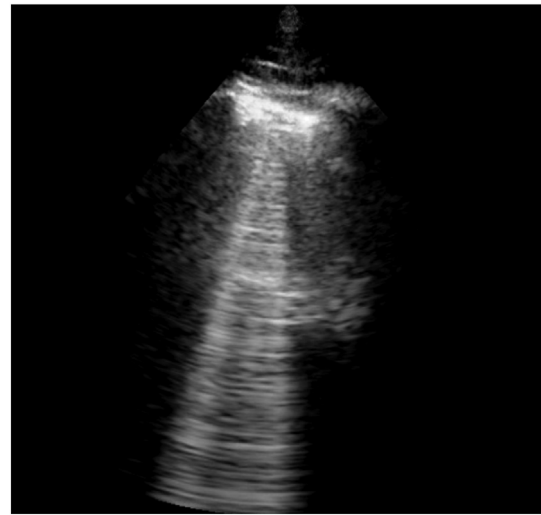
B-lines in lung ultrasound. B-lines indicating interstitial syndrome, consistent with acute heart failure. The presence was defined as three or more B-lines in two chest exploration points.
